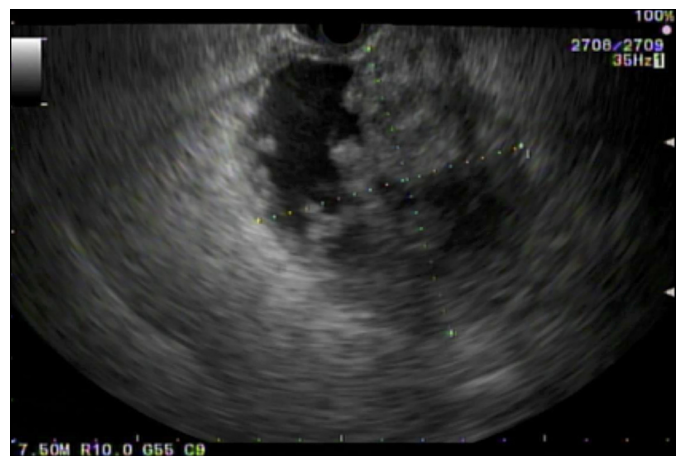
Endoscopic ultrasound showing a 7.1 x 6.7 cm anechoic cystic lesion with an irregularly thick wall and multiple mural nodules in the pancreatic body. No pancreatic duct dilatation or obvious communication with the main pancreatic duct was noted.
